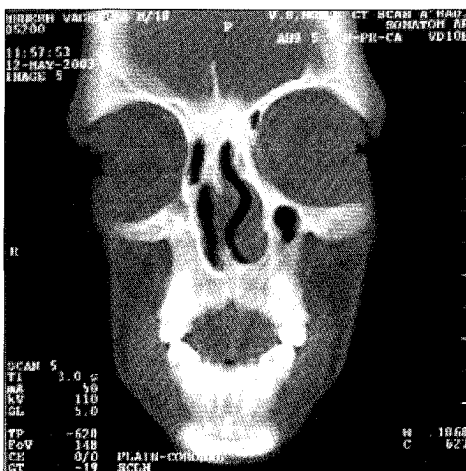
CT Scan: Absence of pneumatization of right maxillary, ethmoid, and sphenoid sinuses
